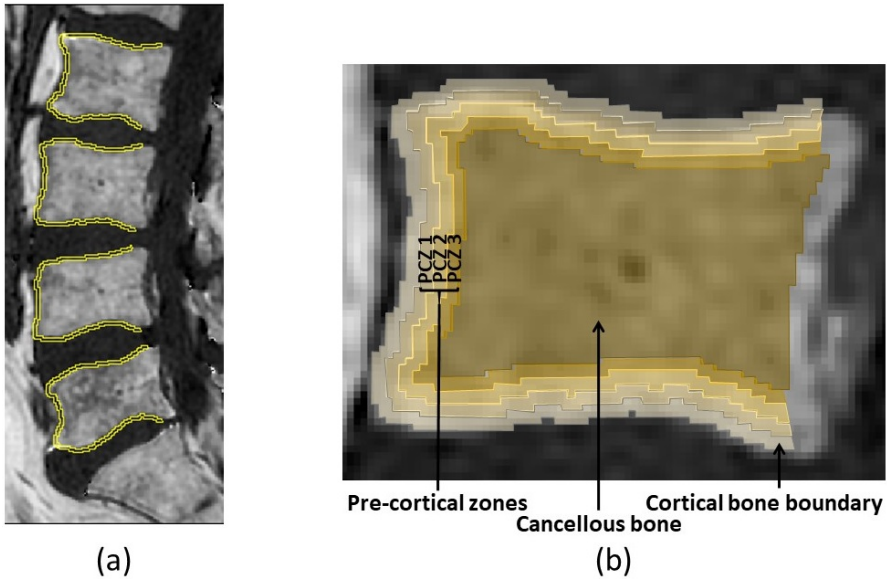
ROI selection process within MR PDFF image. (a) Sagittal cross-sectional MR image of lumbar spine and ROI selection of anterior, inferior and superior cortical bone boundary. (b) Anatomical ROI's including pre-cortical bone and cancellous bone defined.
